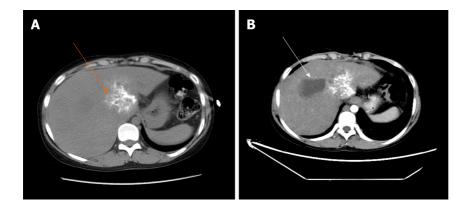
One of the three patients who underwent hepatic hydatid lesion resection again. A, B: Computed tomography scan 1.5 yr after the operation showed that the lesion of the hepatic S1 segment alveolar echinococcosis still existed, as indicated by the orange arrow. Segments S7 and 8 are the residual cystic cavity of the hydatid cyst, which is indicated by the white arrow; B: The S1 segment of the alveolar hydatid lesions invaded the retrohepatic inferior vena cava. The liver showed congestion-like changes. The blue arrow indicates the retrohepatic inferior vena cava.
